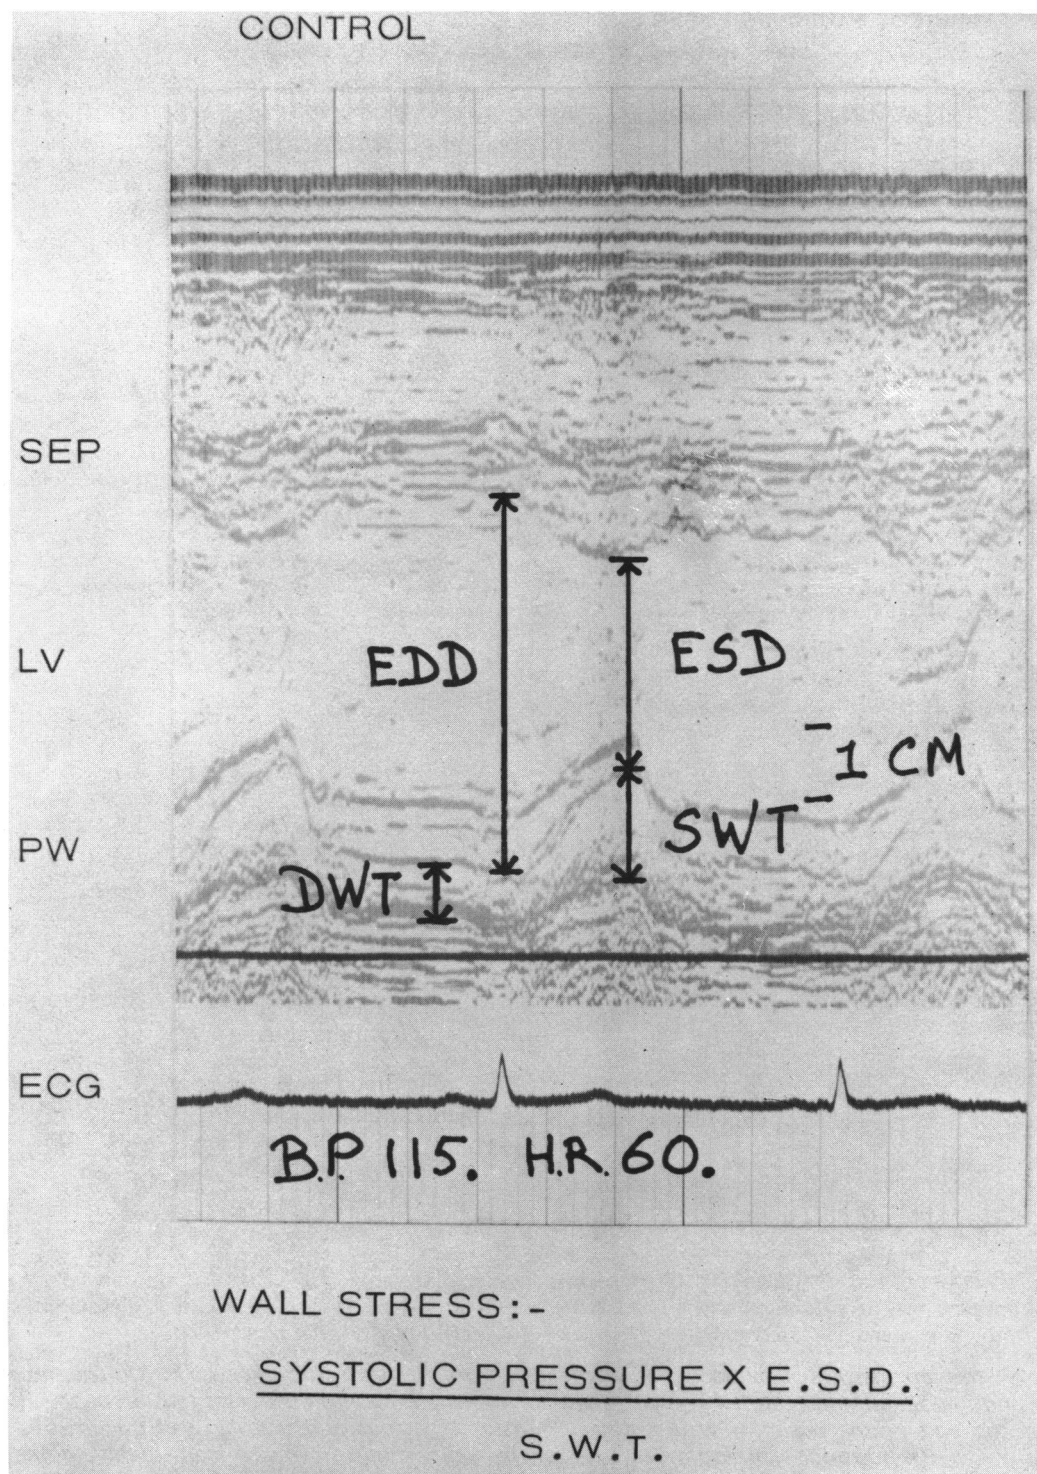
The standard echocardiogram measurements that were made.
